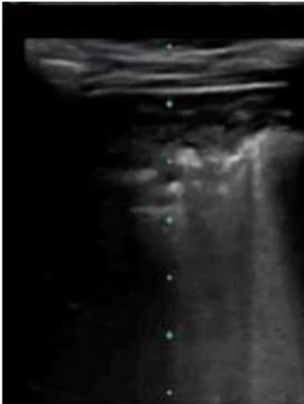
Ultrasound of left lower lobe of lung showing subpleural consolidations and B-lines
